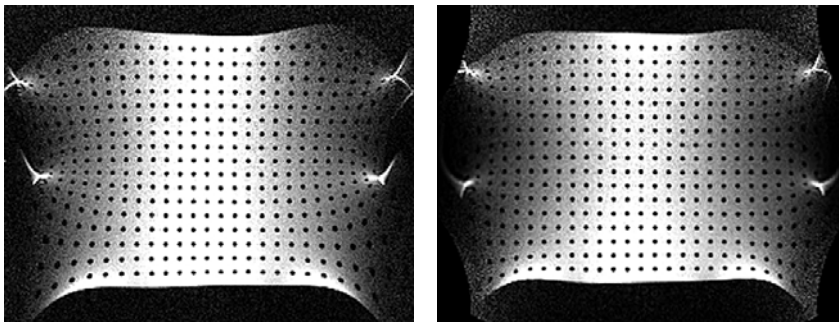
MR image (0.2 T) showing the typical “pillow-shaped” geometric distortion of a grid of equidistant tubes. The distance between tube centers is 1.5 cm. The left and right panels display, respectively, the distortion pattern before and after correction of in-plane distortion generated by static field inhomogeneity and gradient non-linearity using a technique provided by the manufacturer.
